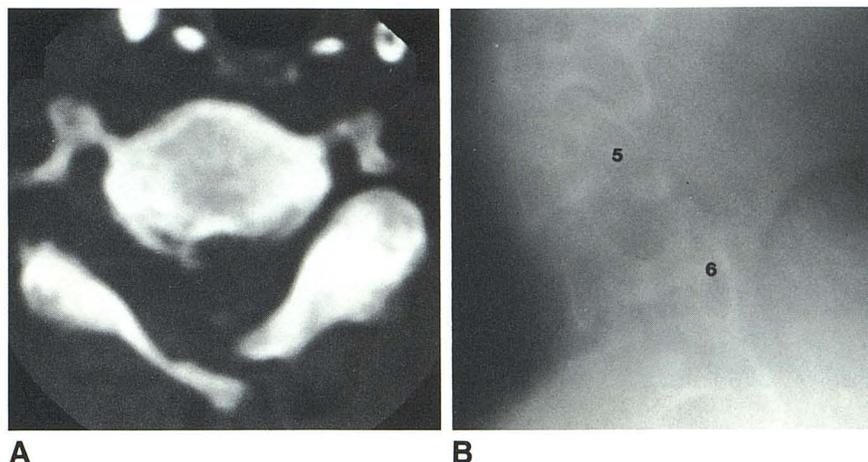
Perched right facet joint. In axial CT image (A), narrow dimension and flat anterior surface of right articular pillar are signs of subluxation. Tomogram (B) shows abnormal relation of inferior articular process of C5 and superior articular process of C6.
